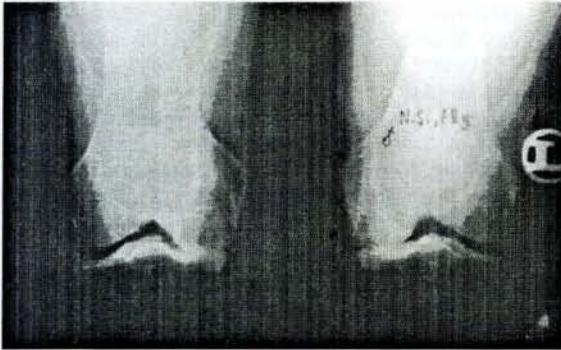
Preoperative 45° flexion weight-bearing PA X-ray
